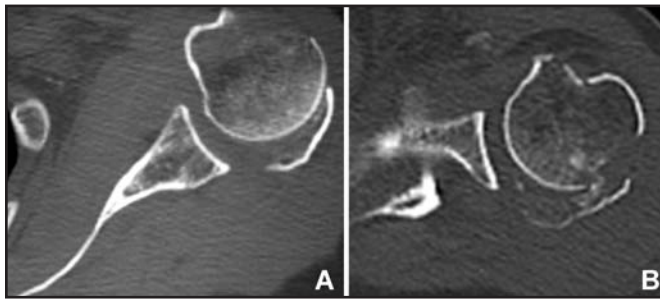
Humeral head orientation in relation to greater tuberosity fracture displacement. (A) Lack of contact between both joint surfaces in the axial plane means a full fracture of one or both tuberosities, leaving dominion to the antagonist muscle, and a non-impacted cephalodiaphyseal relationship. This fracture frequently involves the greater tuberosity with the humeral head in 120° retroversion in the epicondilean-epitroclear axis, and a 90° apex posterior rotation due to subscapular muscle tendon forces. (B) The sufficient orientation of the humeral head with a posterior displacement of the greater tuberosity implies a cephalodiaphyseal impactation. CT scan, axial view.
